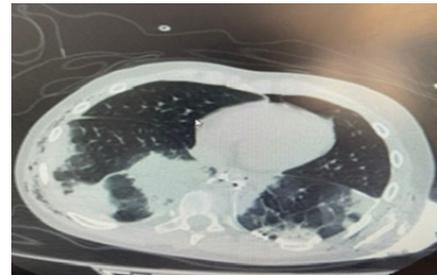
Postoperative CT scan after endoscopic stent placement demonstrating containment of the esophageal leak.
